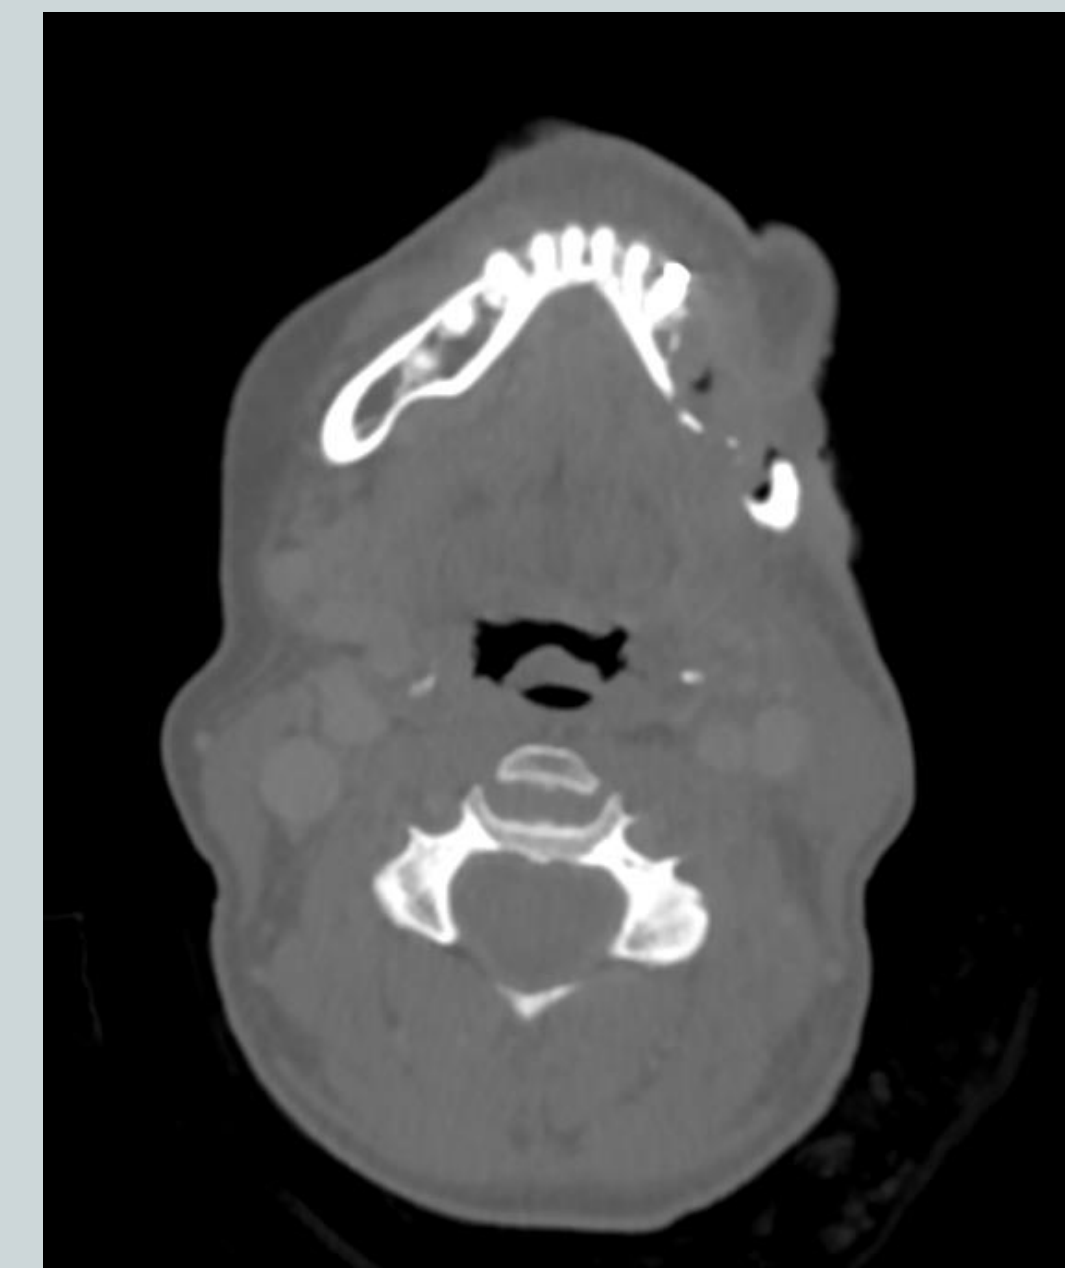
Axial CT of study patient demonstrating fragmentation and bony erosion of the left mandibular body with situlous tracts extending to the skin surface overlying the area of ORN.
